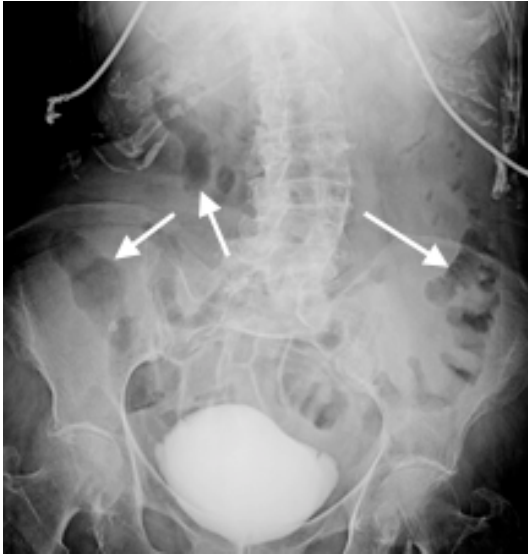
Abdominal x-ray showing "thumbprinting" (arrows) indicative of colonic wall edema.
